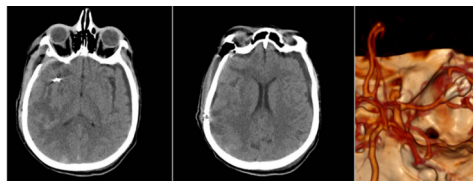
a,b Axial noncontrast-enhanced computed tomography (CT) after bone flap reimplantation; c. – Control CT angiography showed satisfactory clip position complete occlusion of aneurysm (Department of Radiology, Clinical Center University of Sarajevo 2016)
